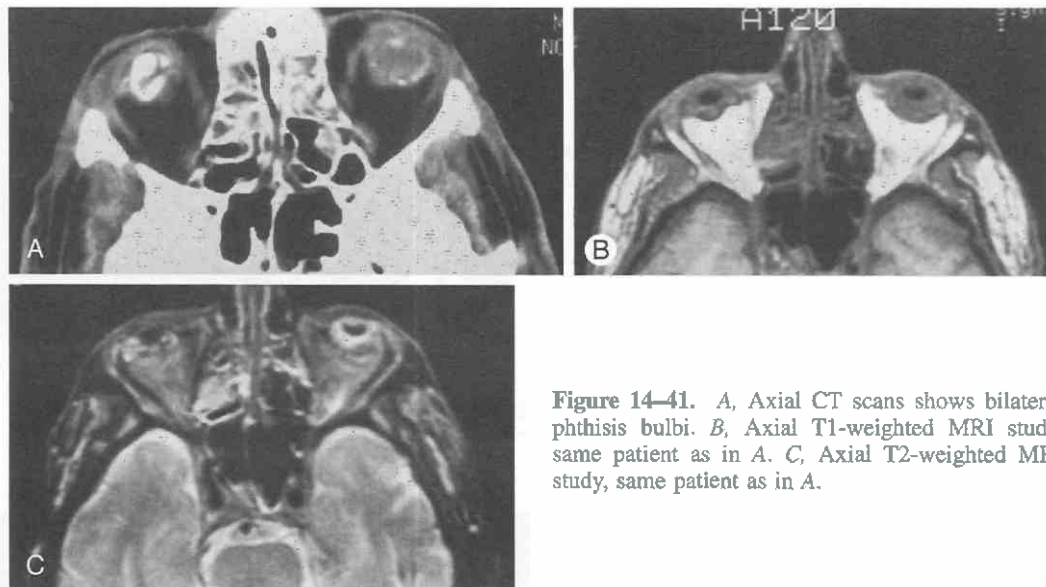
A, Axial CT scans shows bilateral phthisis bulbi. B, Axial T1-weighted MRI study, same patient as in A. C, Axial T2-weighted MRI study, same patient as in A.
